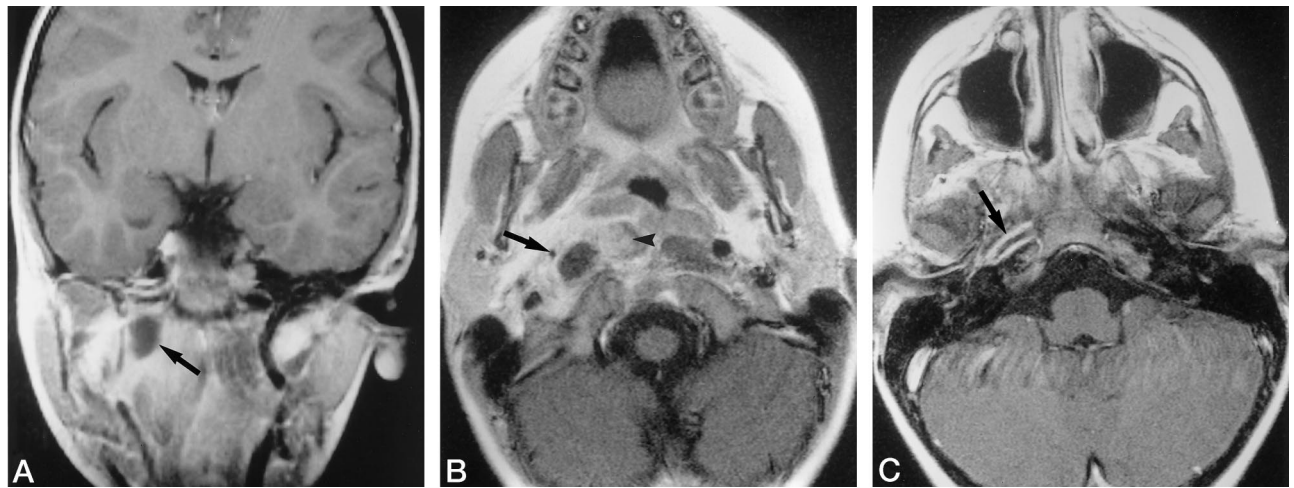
Contrast-enhanced T1-weighted spin-echo MR images in coronal (A) and transverse (B-E) planes show carotid arteritis complicating a retropharyngeal abscess in a 4-year-old child, with complete resolution after surgery.
